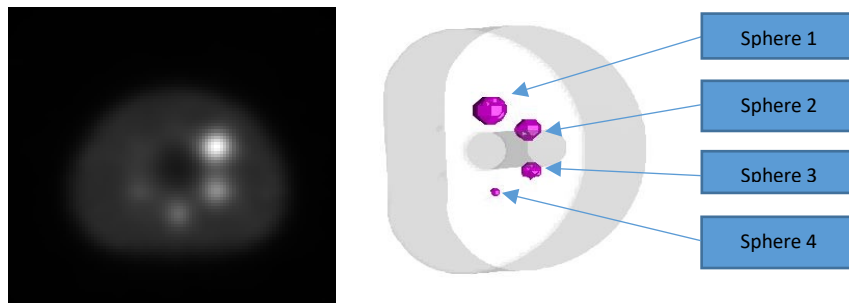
Three-dimensional SPECT/CT images
